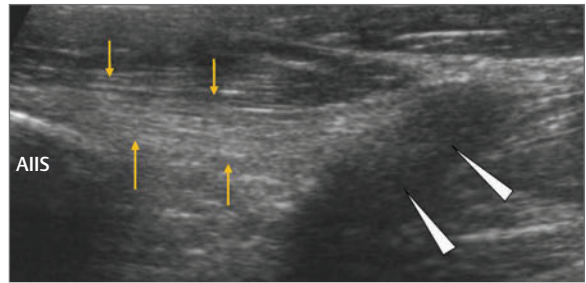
Ultrasound image of the anterior aspect of the hip and the anterior inferior iliac spine (AIIS). The tendon of rectus femoris has two separate attachments, a direct head from the AIIS (yellow arrows) and a deeper attachment from the anterior superior acetabulum (white arrowheads). This deeper indirect attachment can be seen on imaging as a low echo region due to anisotropy because of the fiber orientation in relation to the probe. White arrowheads, rectus femoris tendon (indirect tendon); yellow arrows, rectus femoris tendon (direct tendon).
